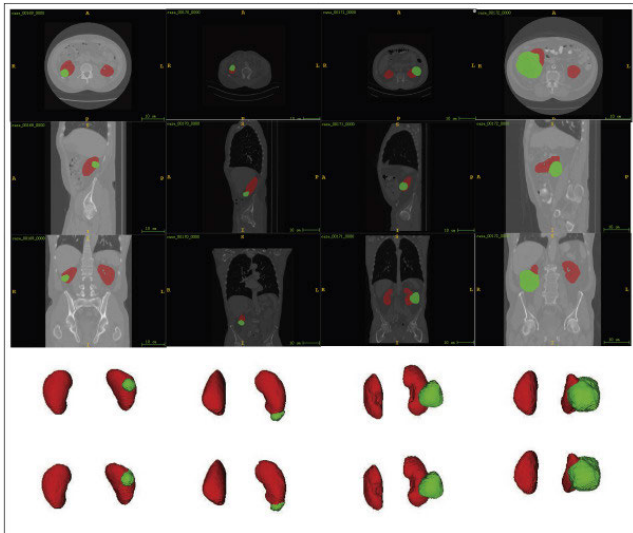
Segmentation of kidney and tumor from reconstructed 3D CT scans.
